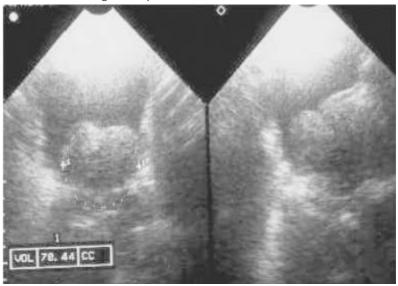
Transabdominal ultrasound showing significant Intravesical Prostatic Protrusion (IPP)
